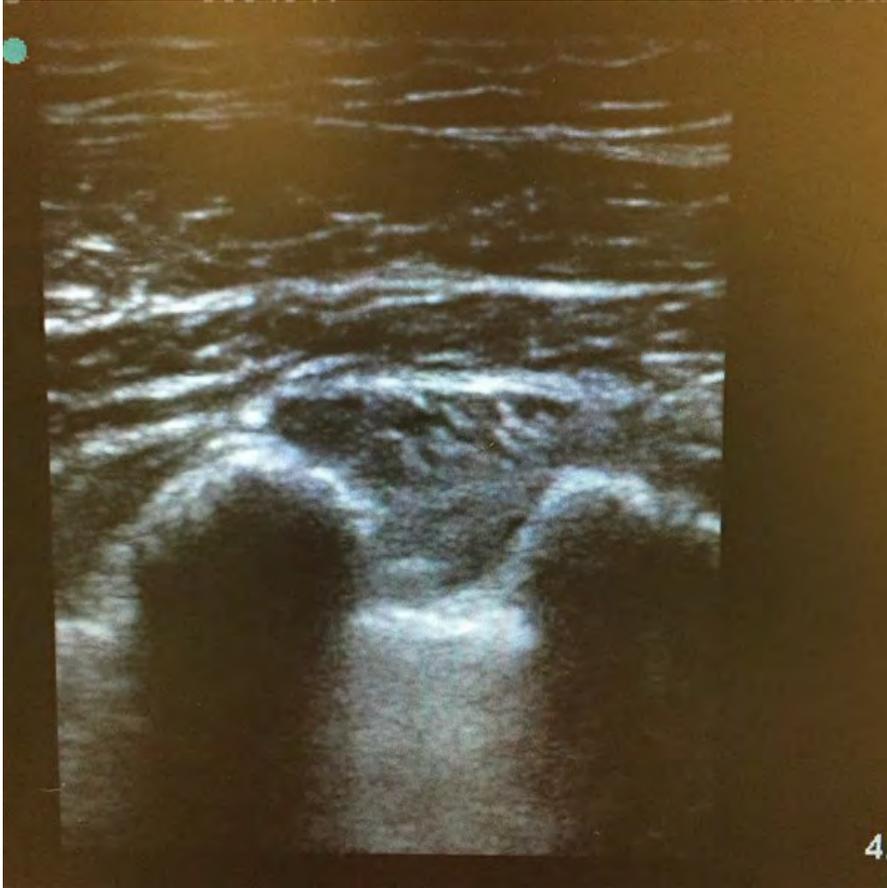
Ultrasound visualization for pectoral nerve block.
